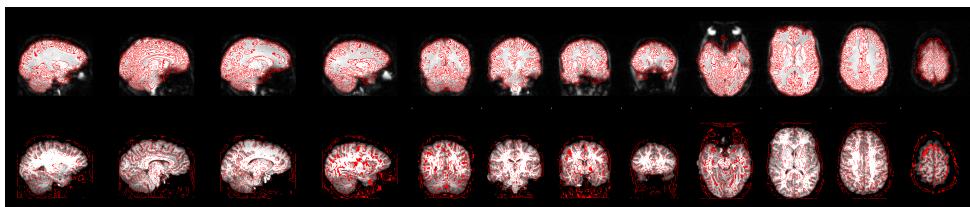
Registration of the functional MRI data of run 1 to the structural MRI data using full search & 3 DOF
